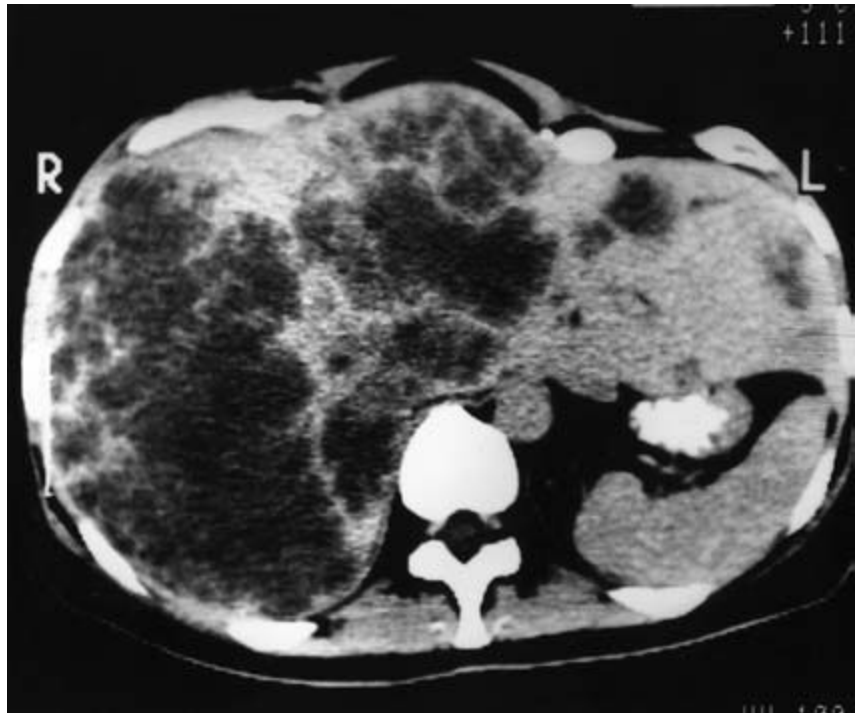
Haemangioma. CT shows a giant benign haemangioma in the right lobe. A few small lesions are seen in the left lobe. The lesions filled in completely after intravenous contrast.
